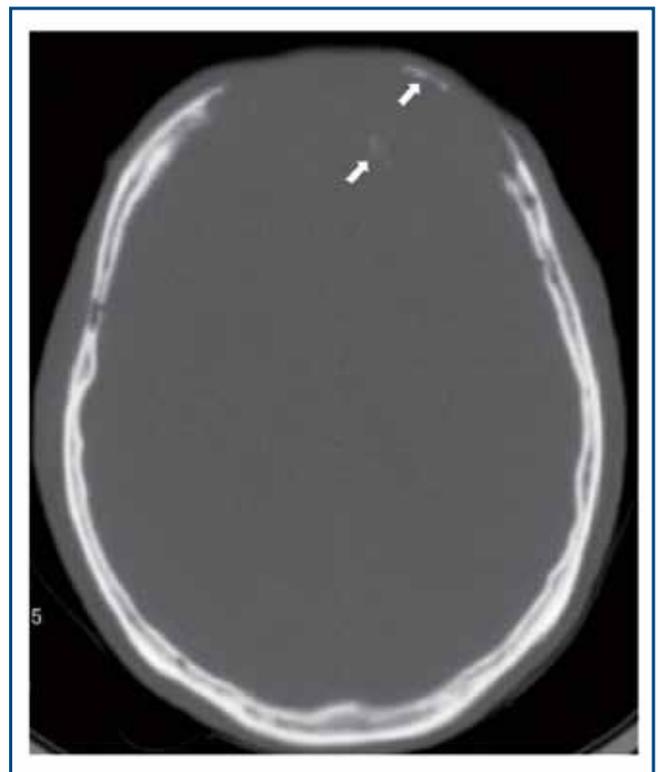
Transversal CT scan shows a large osteolytic lesion with small remaining bone fragments (arrows) in it.
